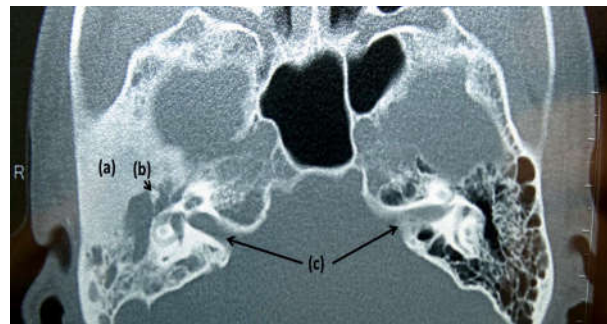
CT Scan in axial section showing (a) Fibrous dysplasia in right temporal bone, (b) Head of malleus in attic, (c) Internal auditory meatus
